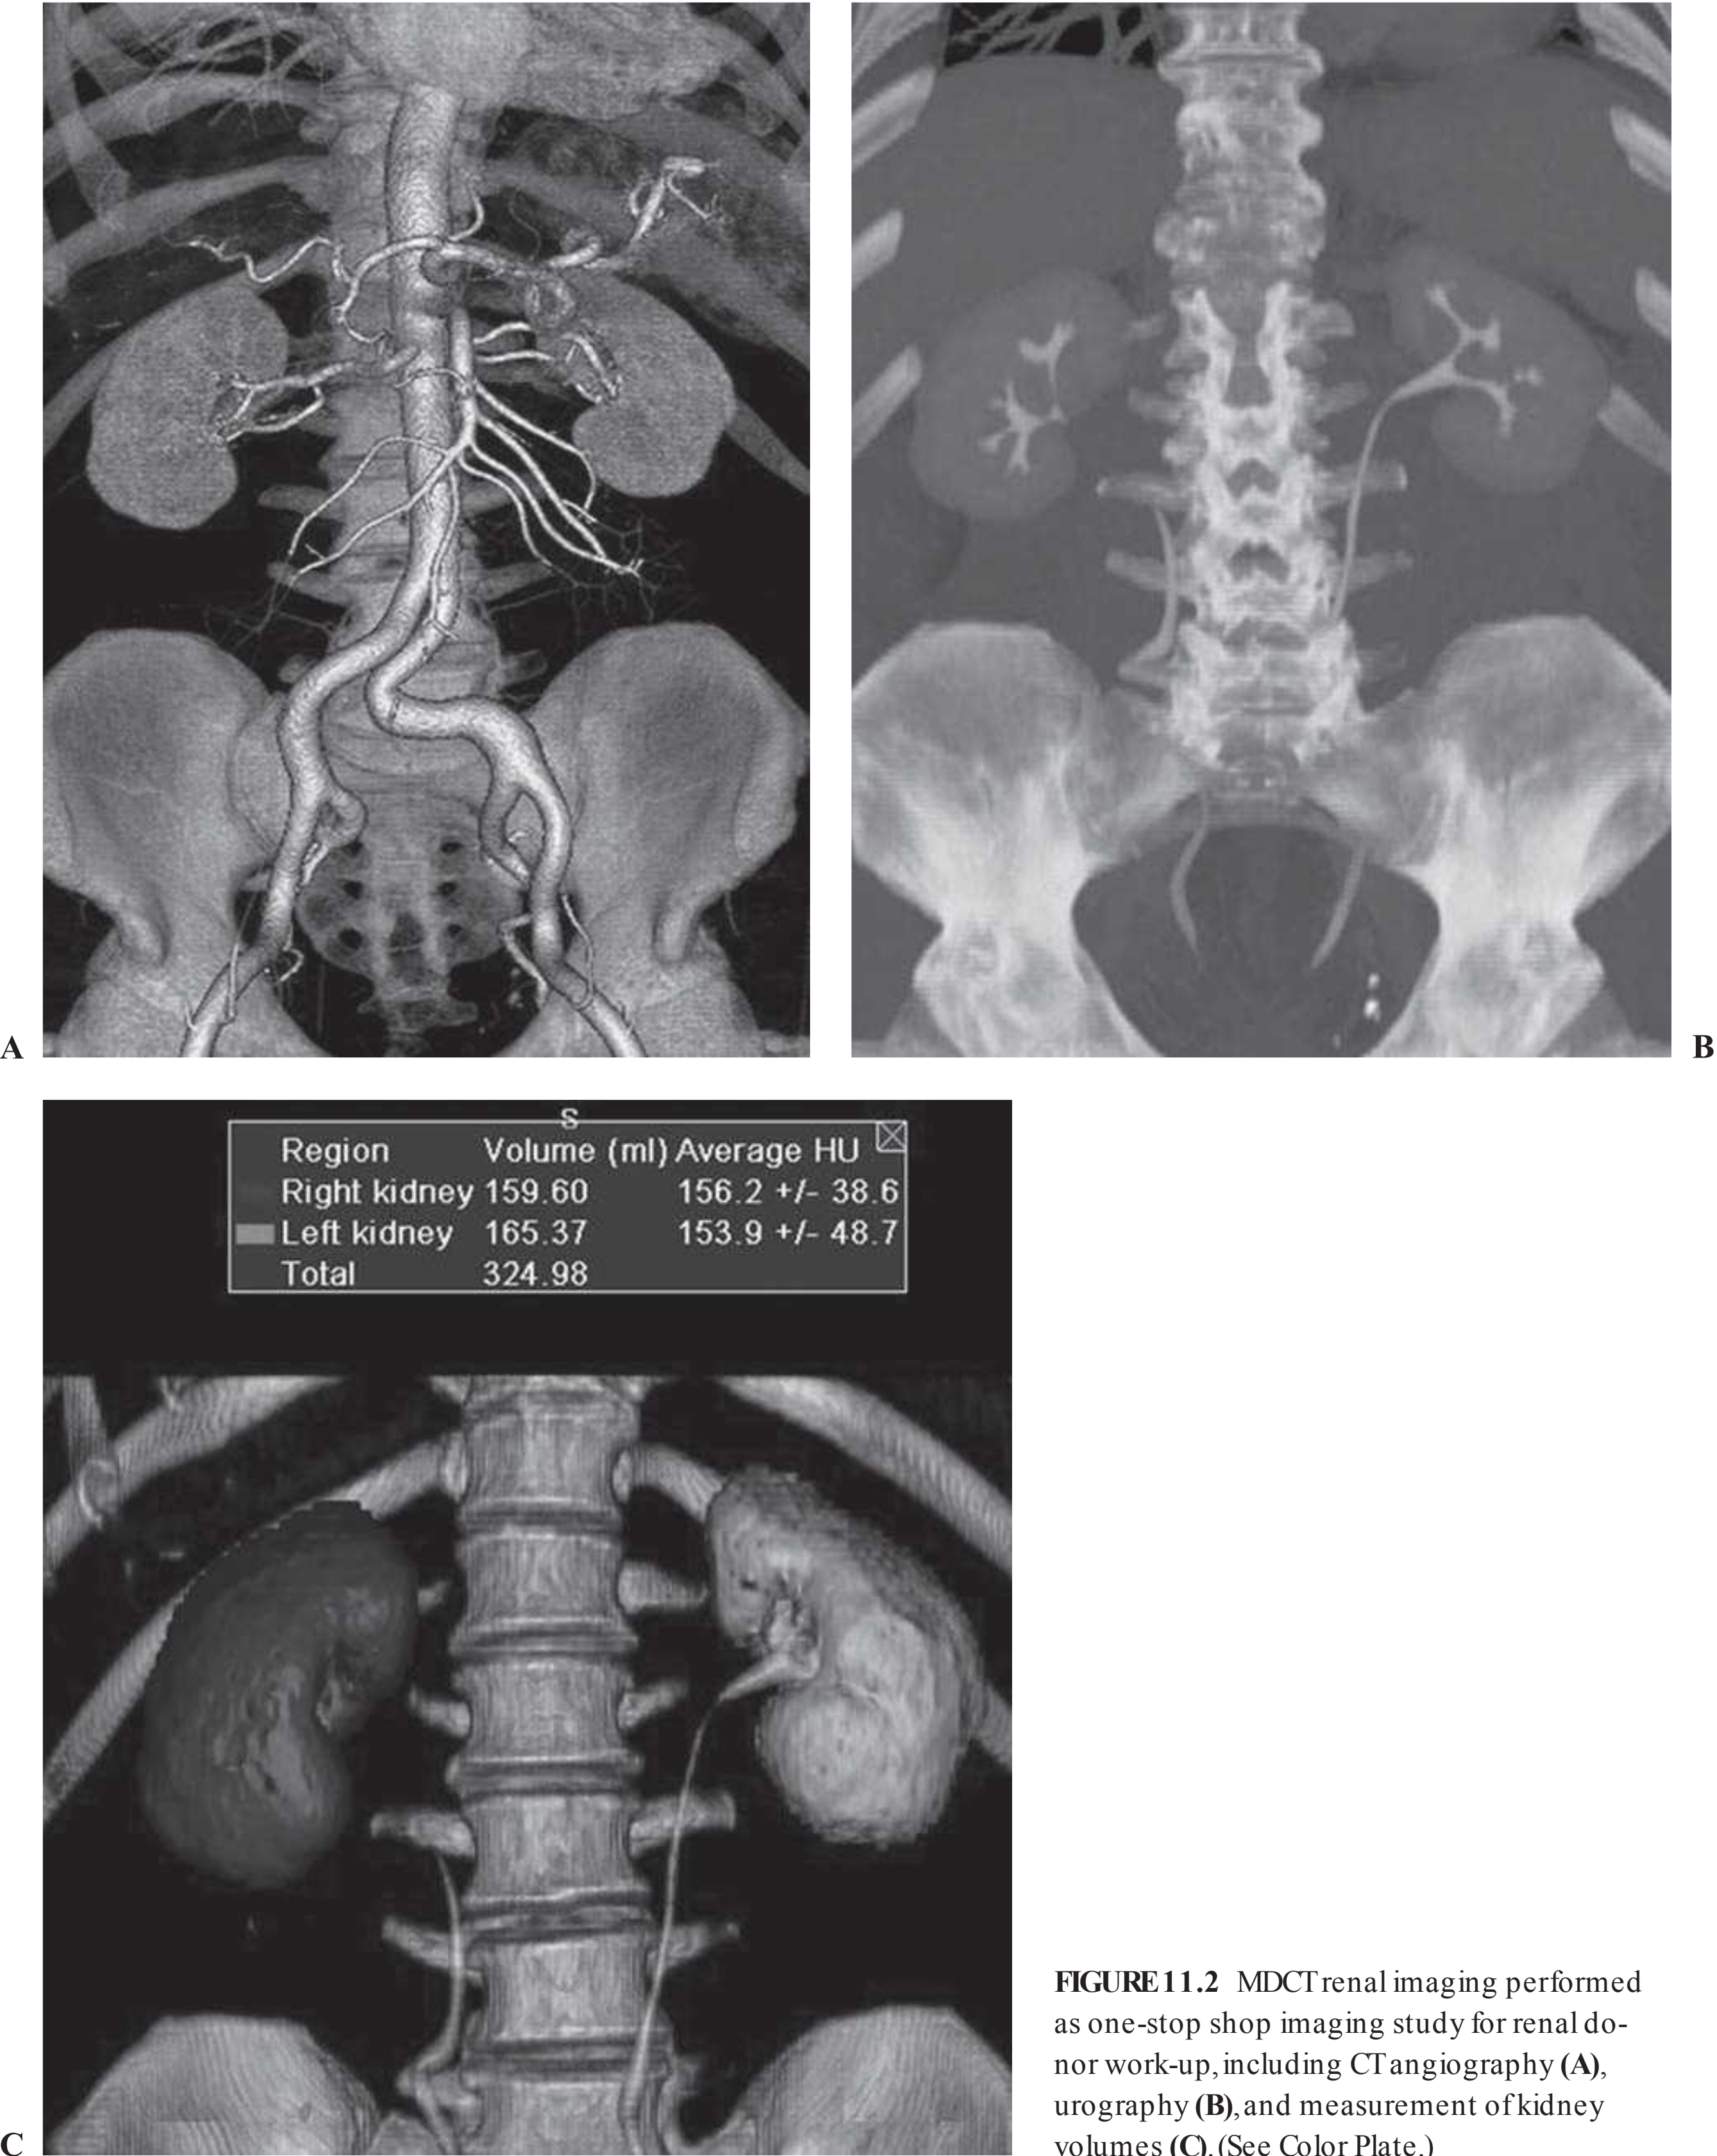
MDCT renal imaging performed as one-stop shop imaging study for renal donor work-up, including CT angiography (A), urography (B), and measurement of kidney volumes (C). (See Color Plate.)
